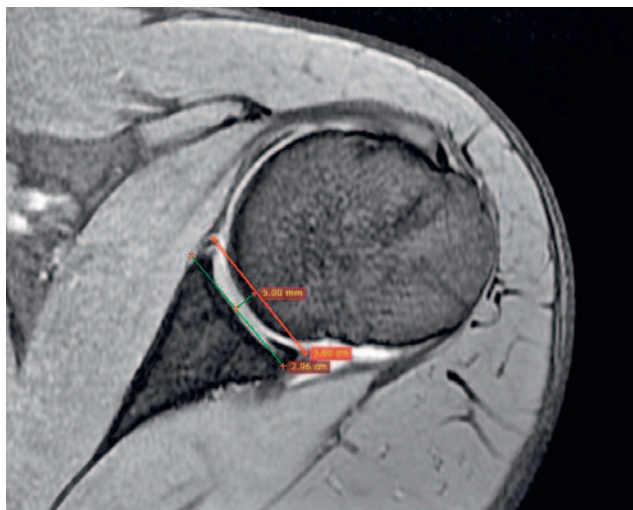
Measurement of the glenoid depth on axial magnetic resonance image.
